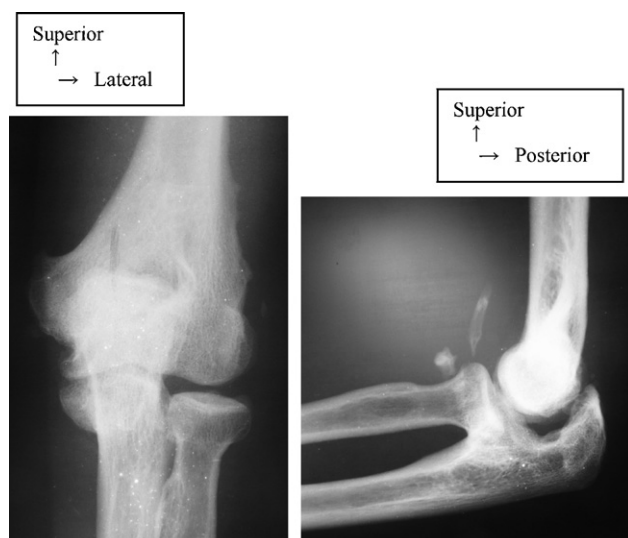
A/P and lateral X-rays at 24 months after the surgery.
